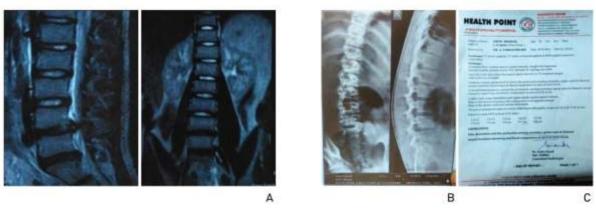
MRI and X-Ray findings before administration of homeopathic medicine.
